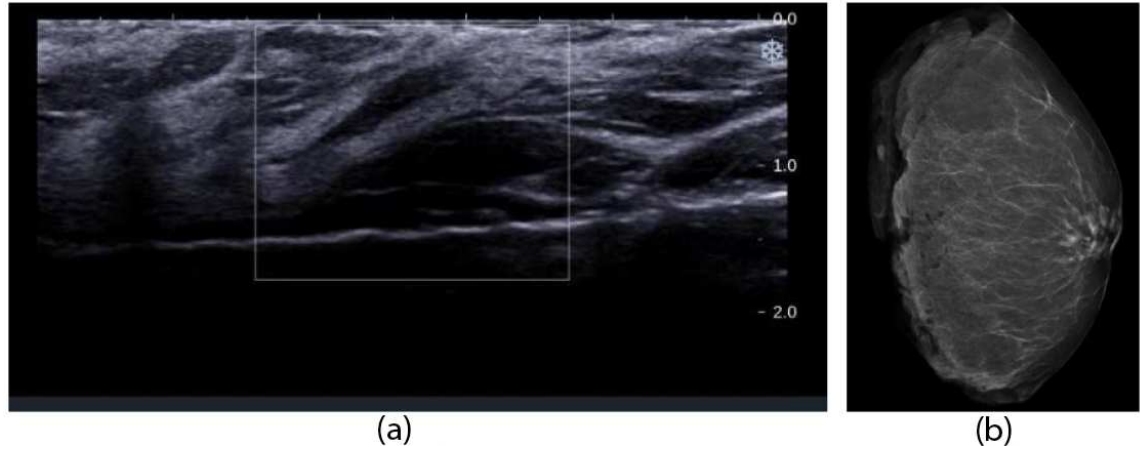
a) US image of the whole soft-embalmed human breast. b) X-Ray image of the predominantly fatty whole soft-embalmed human breast.
